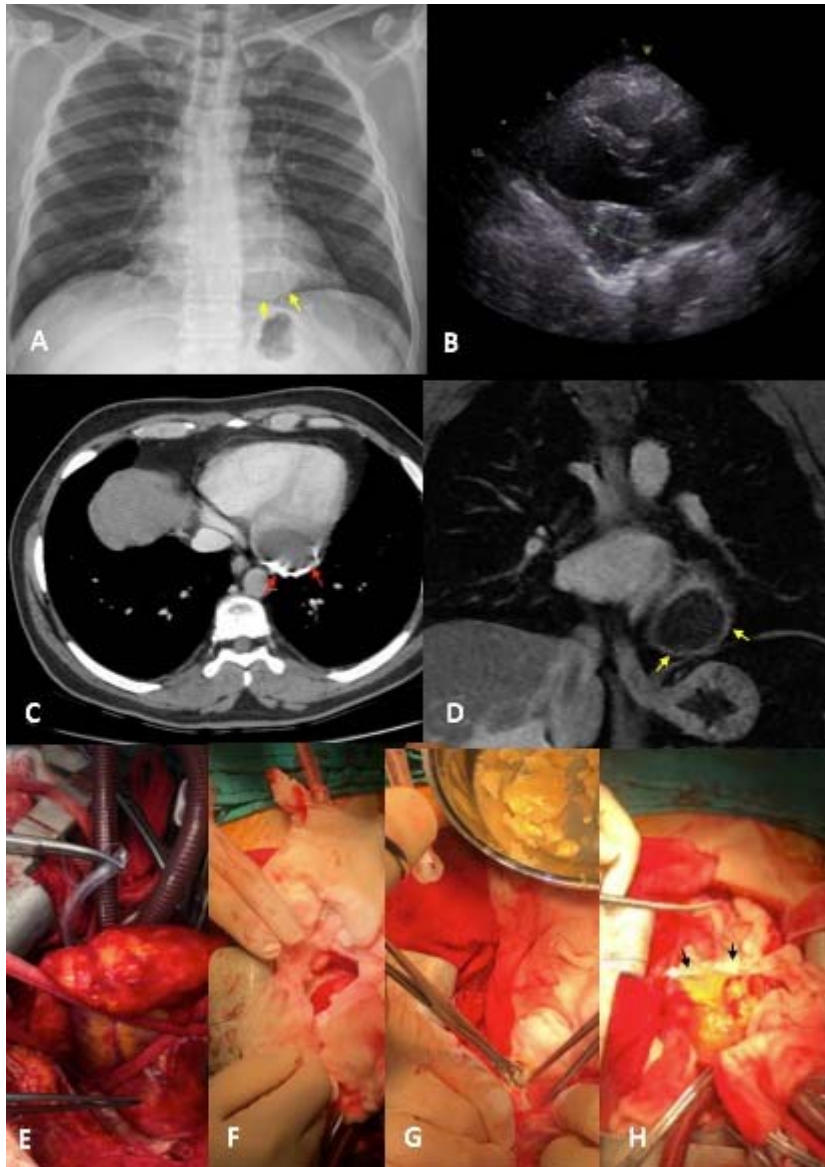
Images of chest X-ray (A), TEE (B) and MRI (C, D) showing the cyst (arrows). In the surgical field, the placement of hypertonic saline solution-soaked sponges into the pericardial space, removal of cystic content with germinative membrane, and obliteration with pledged mattress sutures (arrows) is showed (E-H).
